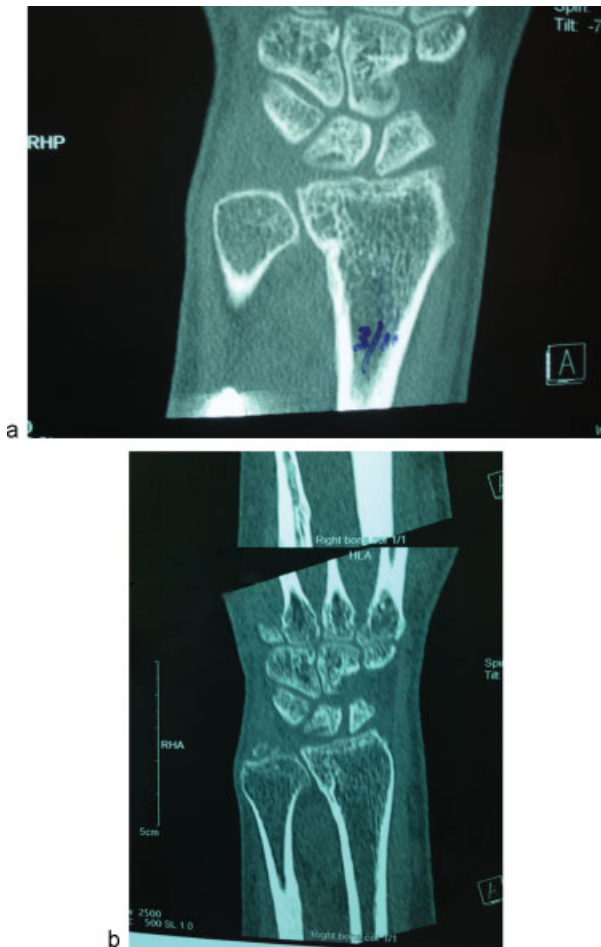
(a) Coronal CT image 9 months after osteotomy. (b) Coronal CT image 3 years after osteotomy.
